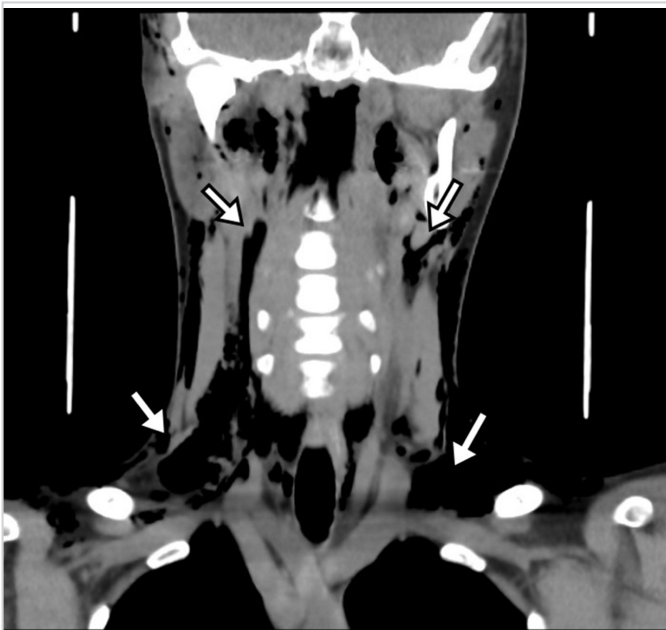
Computed tomography scan of the patient reveals the presence of extensive air (arrows) within the fascial planes of the head and neck
